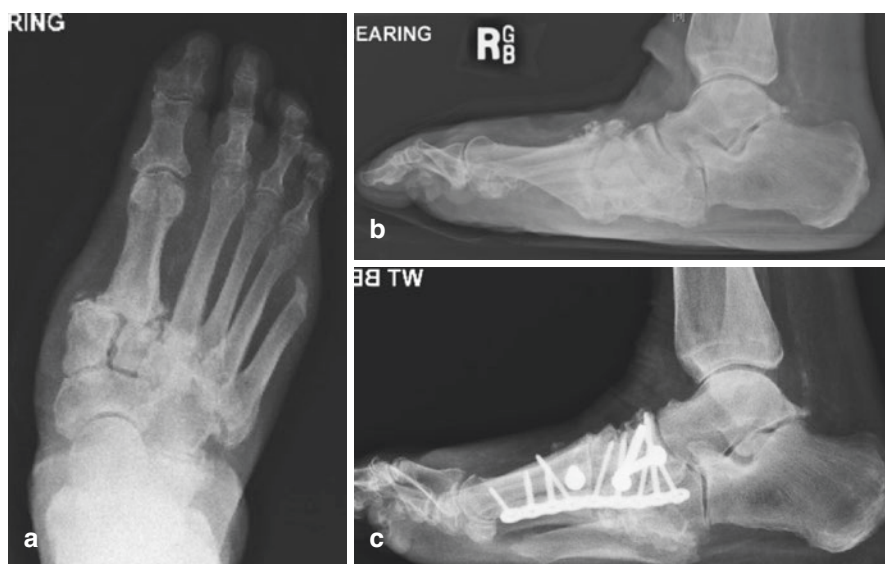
DP (a) and lateral (b) radiographs showing CN of midfoot, predominantly affecting the Lisfranc articulation. Post-operative lateral radiograph (c) showing the deformity correction and plantar plate fixation of the medial column, sparing the talonavicular joint
